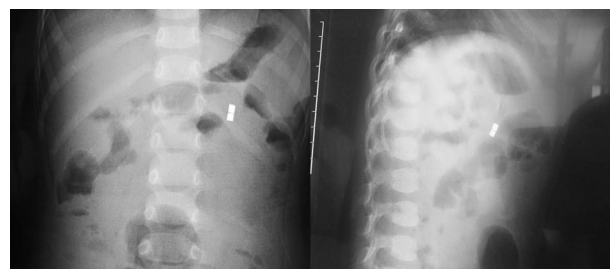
The anteroposterior and lateral X-ray films of the abdomen, showing a ‘gap’ among the small magnetic foreign bodies.
